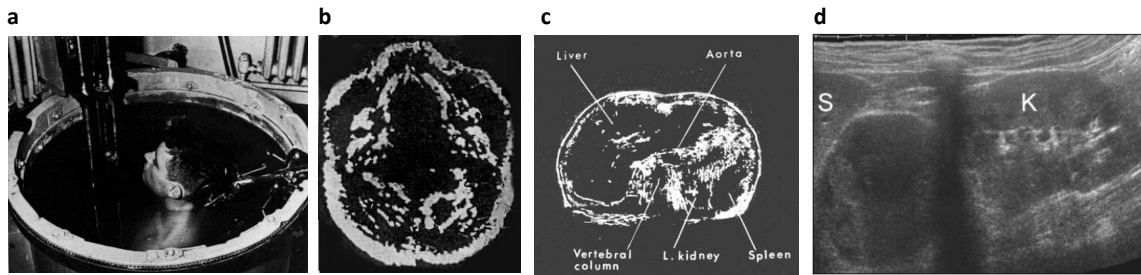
Historical development of wide field-of-view ultrasound imaging. a, Water immersion acoustic imaging system in 1957. b, Resulting “sonagram” of the human neck [15]. c, Early bistable images from a single-element articulating arm imaging approach [13]. d, Extended field-of-view ultrasound images of the abdomen obtained by co-registering multiple B-mode images from a scanned linear probe [14]. S: spleen. K: kidney.
